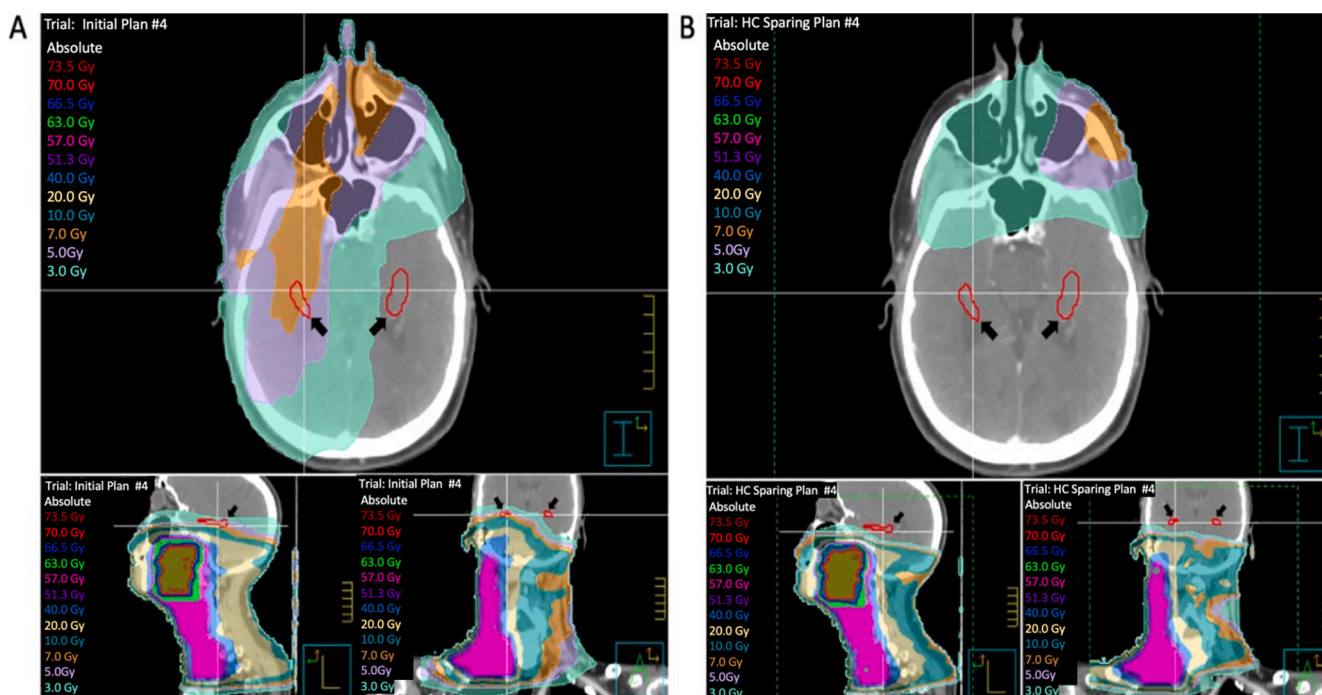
Example of dose distributions in the contoured hippocampus and isodose line in (A) initial plan and (B) HC-sparing plan in axial, coronal and sagittal views on CT image. Black arrow indicates the hippocampus.
